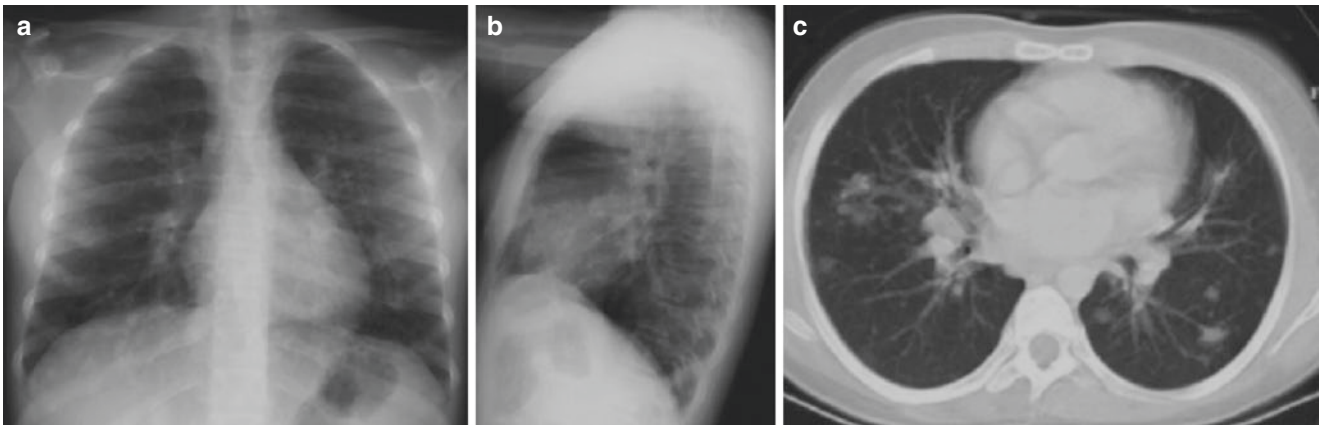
A 20-year-old man with sarcoidosis who presented with pulmonary nodules. Frontal (a) and lateral (b) chest radiographs and axial lung window CT image (c) show multiple ill-defined pulmonary nodules in both lungs
